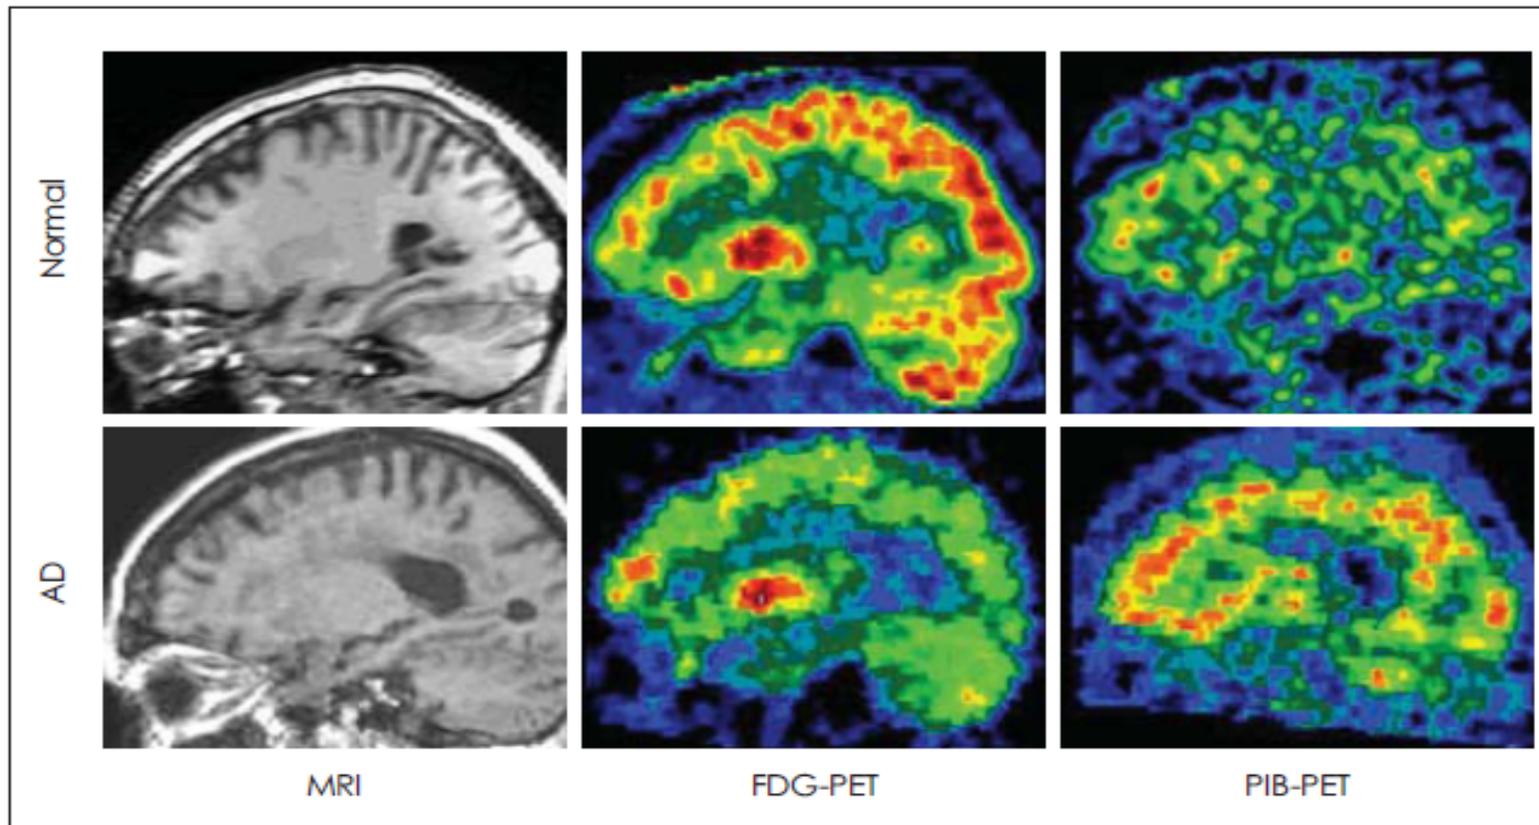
Two representative cases: magnetic resonance image (MRI, left column), FDG-PET (middle column) and PIB-PET (right column) of a normal control (top row) and an AD patient (bottom row). FDG: 2-[¹⁸F]fluoro-2-Deoxy-D-glucose, PIB: Pittsburgh Compound-B, AD: Alzheimer's disease.
